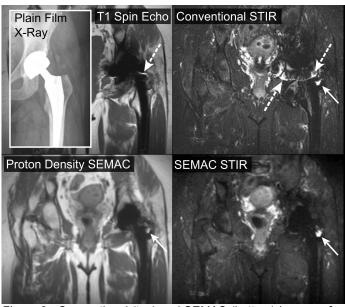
Conventional (top) and SEMAC (bottom) images of a patient with a total hip replacment. Susceptibility artifacts cause "pile-up" artifacts (dashed arrows) and inaccurate depiction of the implant on conventional MR images. SEMAC images dramatically reduce the distortion, and SEMAC STIR allows fluid near the implant to be unambiguously identified.
